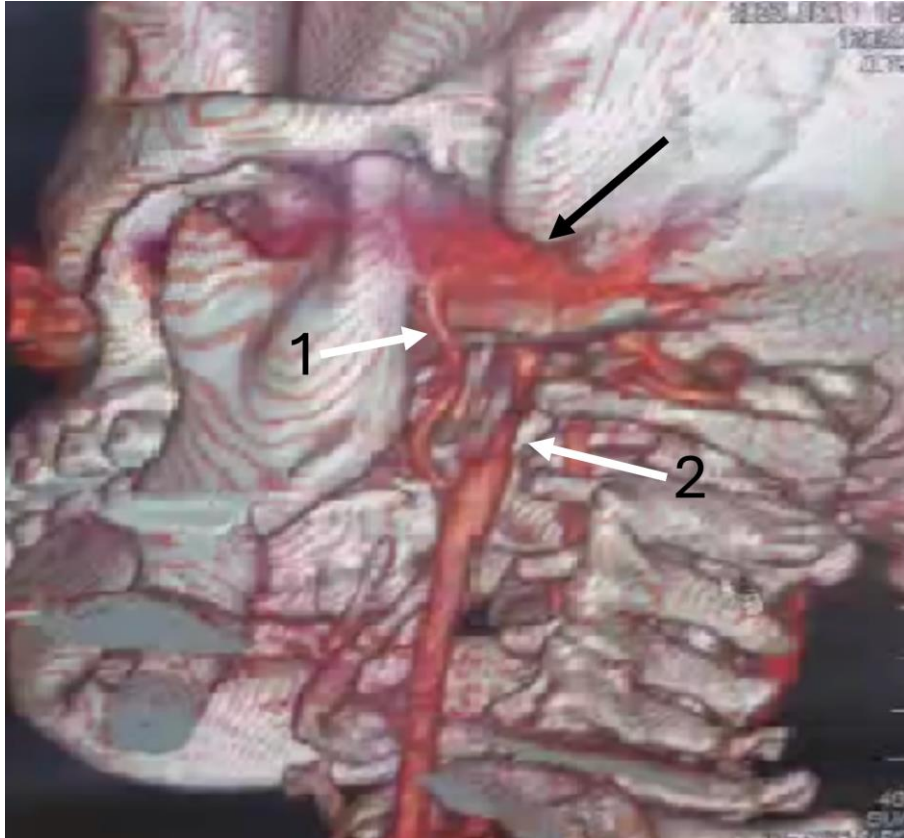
CT angiography, 3D reconstruction, left view. Black arrow: the arrow crossing the pathway of major vessels (internal and external carotid artery). 1. External carotid. 2. Internal carotid.
